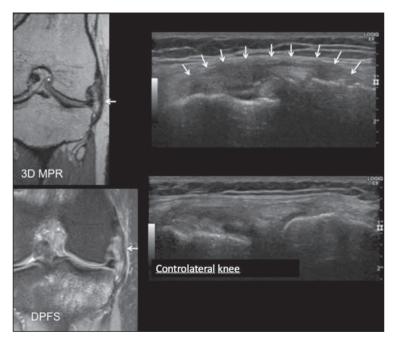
Example of an ALL tear without any bone injury. Severe damage to the ALL under MRI and ultrasound without any bone injury. The ligament is completely infiltrated and thickened under MRI with a clearly visible pathological hypersignal on the sections using a fat suppression technique. Associated anterior cruciate ligament tear (asterisk). Comparative ultrasound sections clearly show the hypoechoic ligament, which is thickened and distended on the injured side (arrows).
